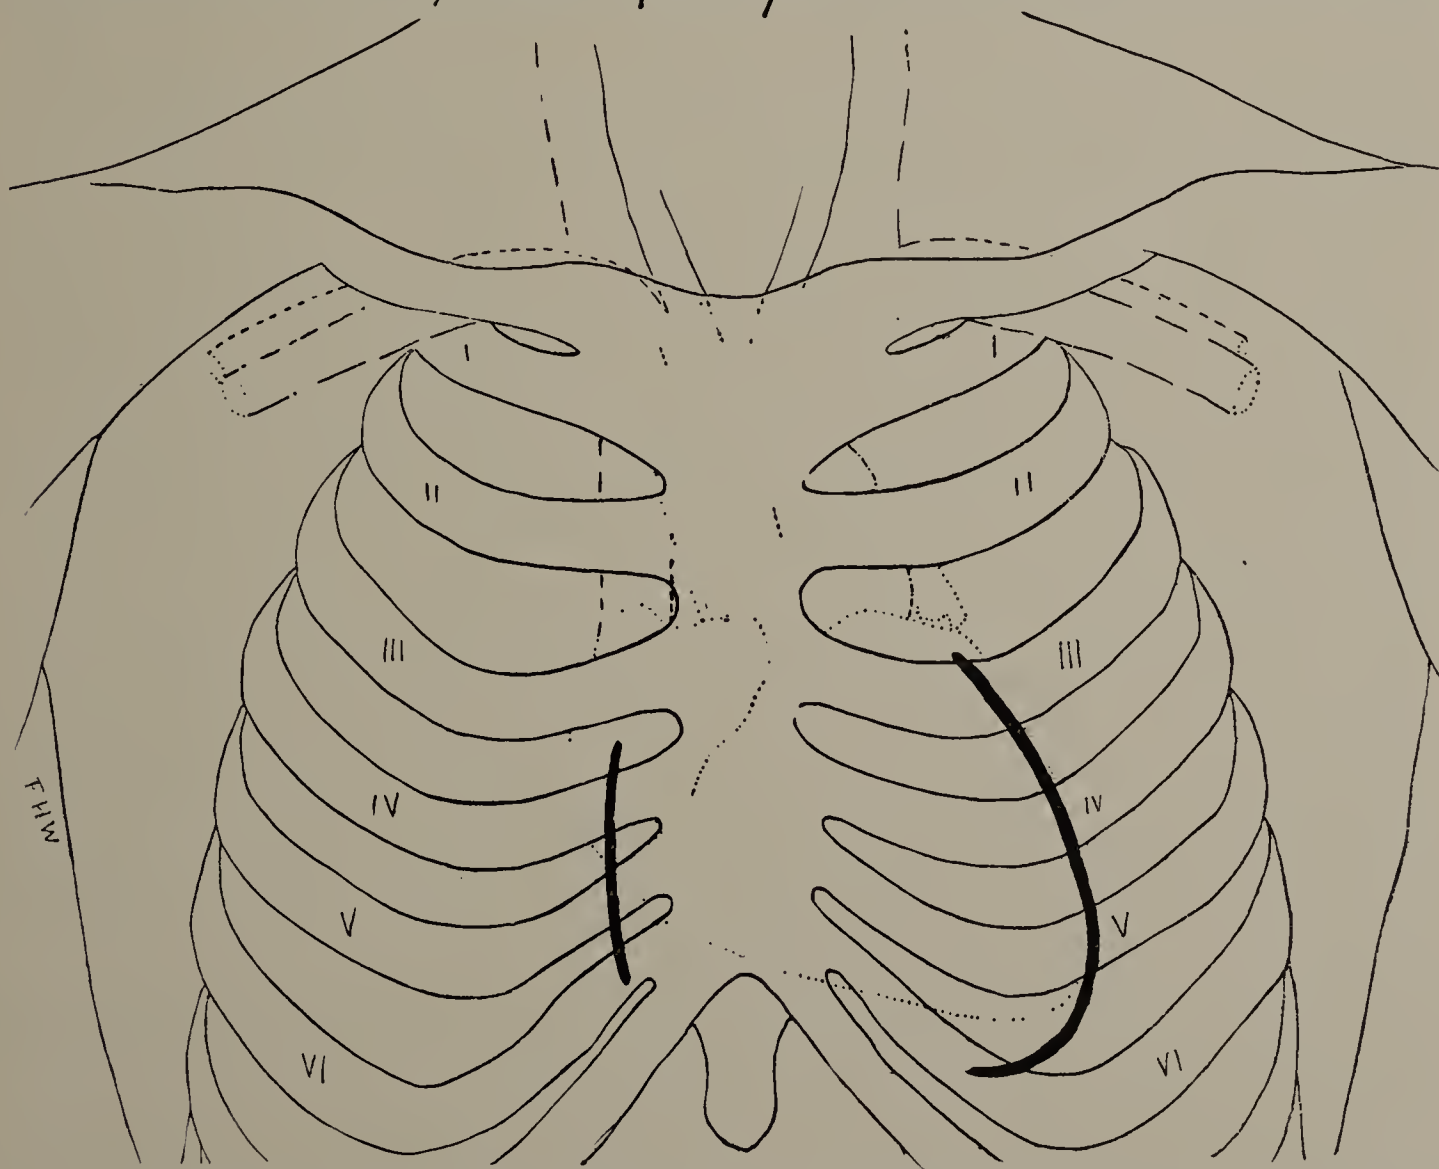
Ella H. Third X-ray examination. (Cut one-third life size.) Lungs now clear. Excursion of diaphragm (lines not given) can be well seen on both sides. Heart smaller in size than on March 22.
